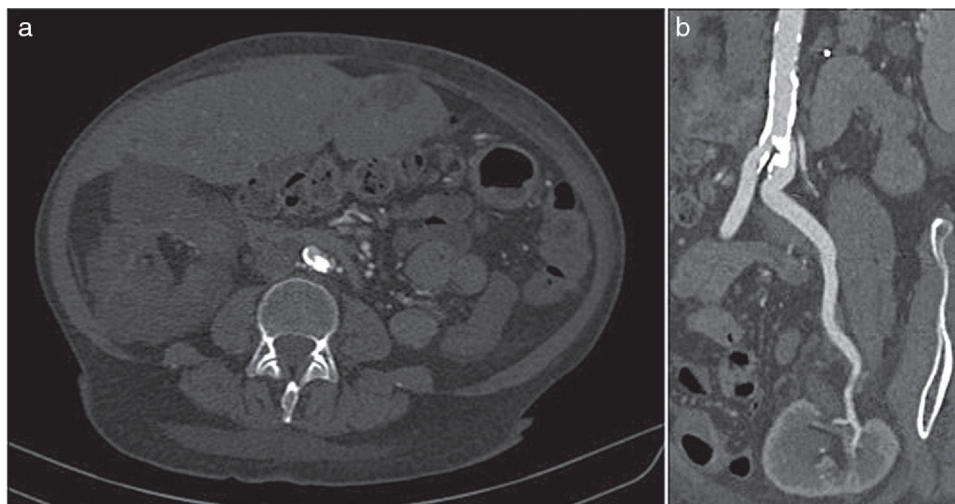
Computed tomographic angiography. (a) In the cross-section, an intraluminal calcified lesion was observed at the origin of the left common iliac artery. (b) In the multilane reconstruction, it is observed permeability without stenosis in the renal artery of the transplanted graft.
